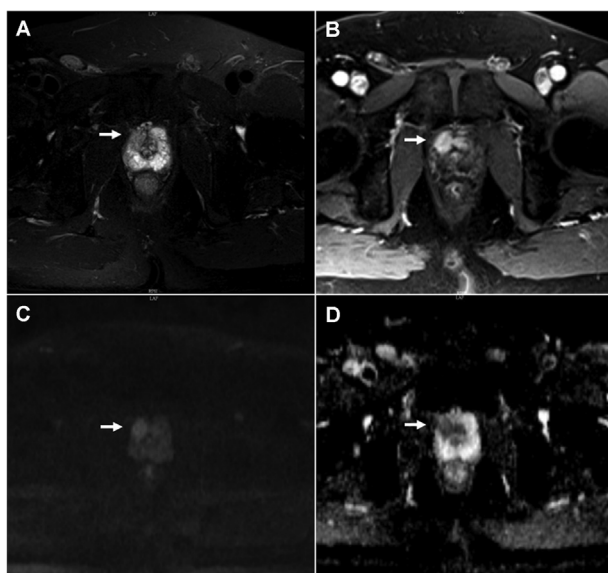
MRI images for the case. (A) Axial T2-weighted magnetic resonance image showing a hypointensity lesion within right peripheral zone (arrow); (B) Post-contrast axial T1-weighted image showing intense enhancement of the lesion; (C and D) Axial diffusion weighted image and apparent diffusion coefficient map showing restricted diffusion.
